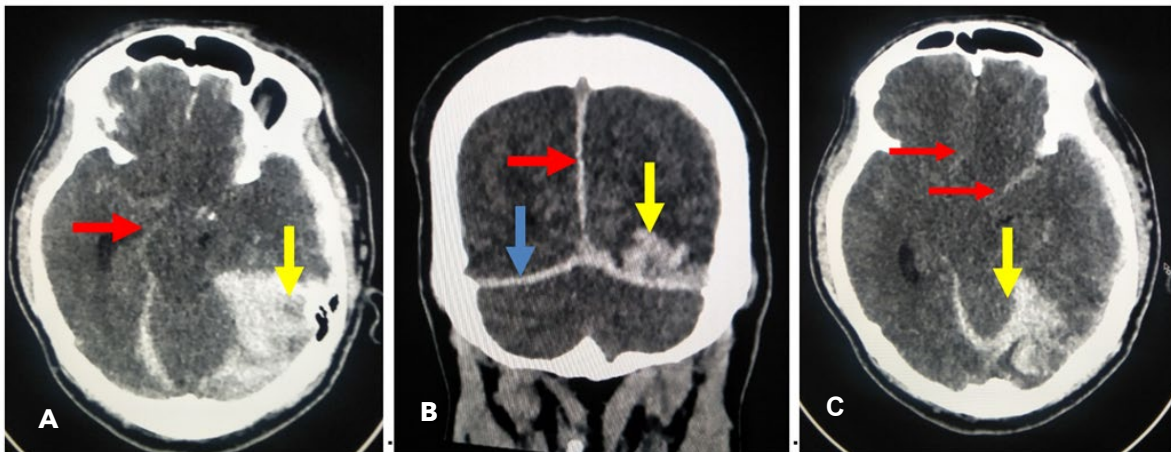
Non-contrast brain CT imaging at symptom onset. (A) Axial section showing hyperdensities in the visualized perimesencephalic cistern (red arrow) and image artifact (yellow arrow). (B) Coronal section showing acute parenchymal bleed (yellow arrow) and subdural hematoma along the tentorium cerebelli (blue arrow) and posterior interhemispheric falx (red arrow). (C) Axial section showing acute parenchymal bleed of approximately 5cc volume in the left occipital lobe (yellow arrow) with subarachnoid extensions (small red arrows).
